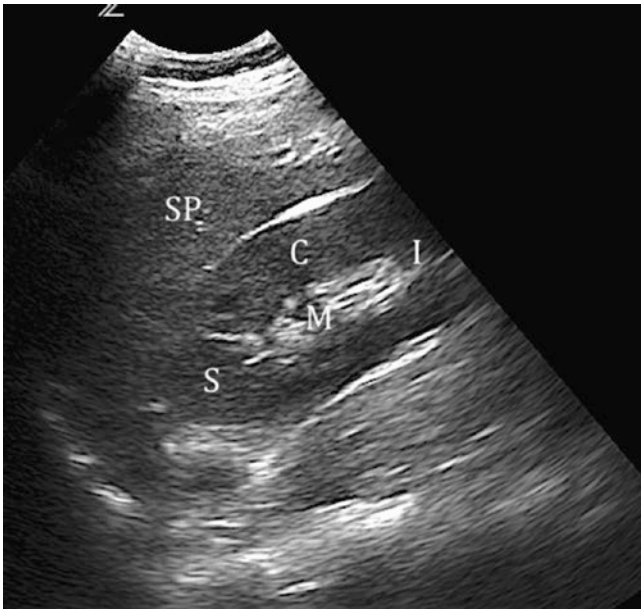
Ultrasound image of the left kidney in the longitudinal plane. A longitudinal view of the kidney should demonstrate the superior (S) and inferior (I) poles, cortex (C), and medulla (M) of the kidney. The spleen (SP) can be seen superior to the kidney. See Video 28.3. (Image courtesy of Stephen Alerhand.)
